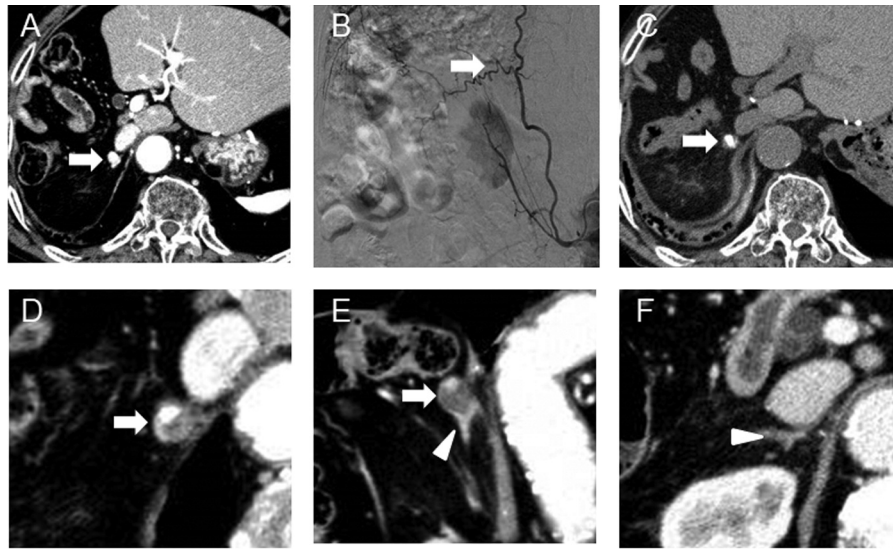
Serial images of the right adrenal metastasis during treatment. (A) Pretreatment contrast-enhanced CT image. (B) Subtraction angiography image before TACE. (C) Non-contrast CT image one week after TACE. Contrast-enhanced axial (D) and coronal (E) CT images in portal phase seven months after TACE. (F) Contrast-enhanced CT image one month after surgery. HCC metastasis (arrow) and adrenal gland (arrowhead).
